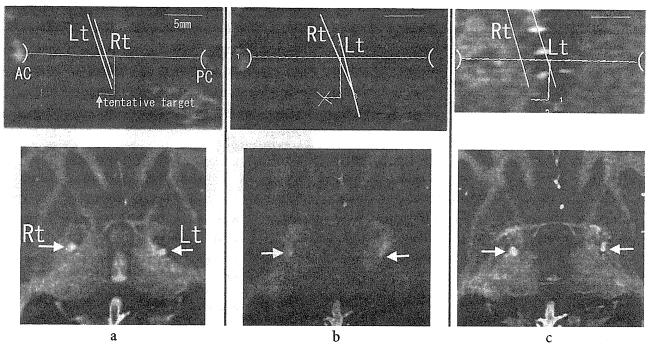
Sagittal (upper panels) and axial (lower panels) planes of brain MRI showing the positions of GPi electrodes. One month (a) and 5 years (b) after the first surgery, and one month after lead replacement (c).
